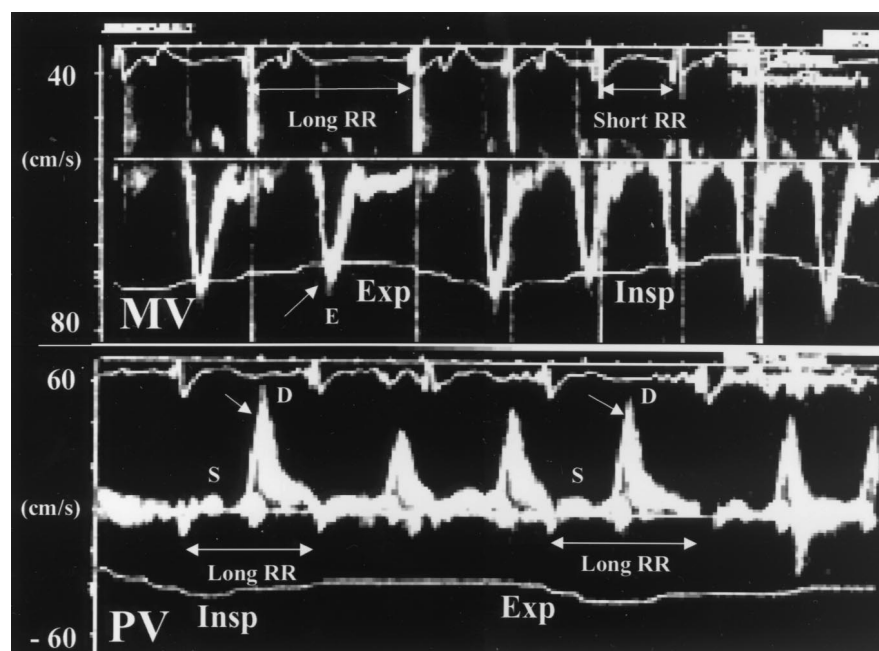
The beat-to-beat change in pulsed Doppler MV and PV velocities in patients with atrial fibrillation without constrictive pericarditis. In the subjects with atrial fibrillation without constrictive pericarditis, early diastolic MV and PV velocities become greater with long filling intervals as shown by white arrows regardless of the phase of respiration. D = pulmonary venous diastolic wave; E = mitral inflow early filling wave; Exp = expiration; Insp = inspiration; MV = mitral inflow; PV = pulmonary venous; S = pulmonary venous systolic wave.
